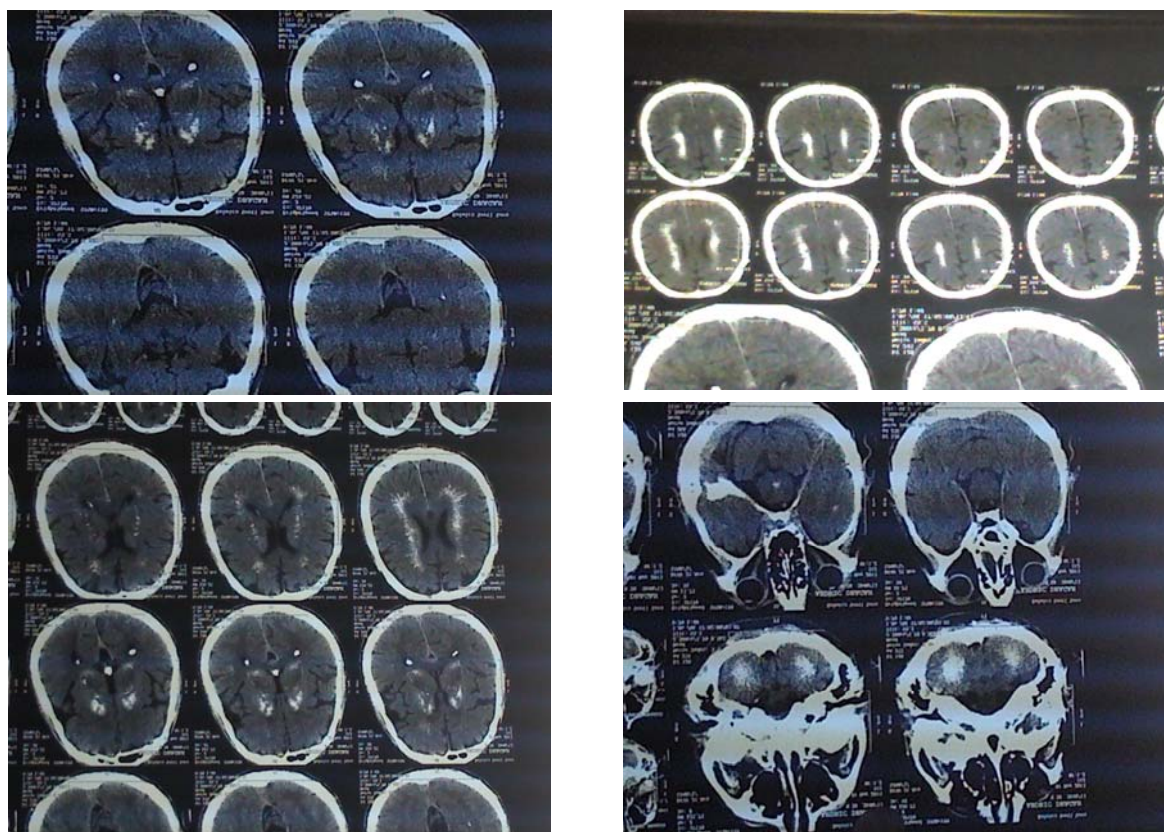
Brain computed tomography (CT) scan revealing bilateral, multiple, symmetric calcifications in the basal ganglia, periventricular and supraventricular, also infratentorial in the cerebellum and pons centrally.
